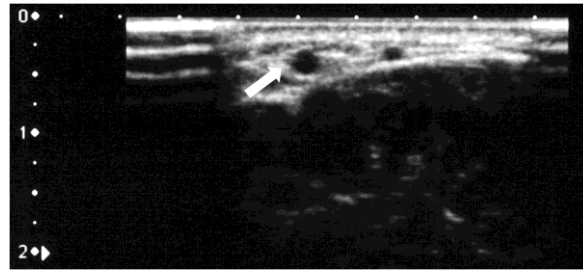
Forearm surface vessels image by ultrasound. White arrow shows median antebrachial vein, which is 2.0 mm in diameter. Surface to vein distance is 5.0 mm.
